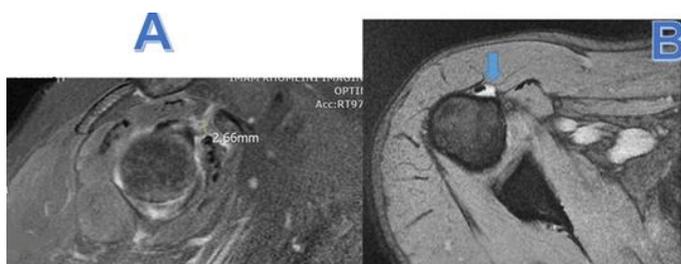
PD fat-suppressed sagittal MRI sequences A: measuring of Coracohumeral ligament (CHL) thickness. B: effusion in the long head of biceps tendon sheath
